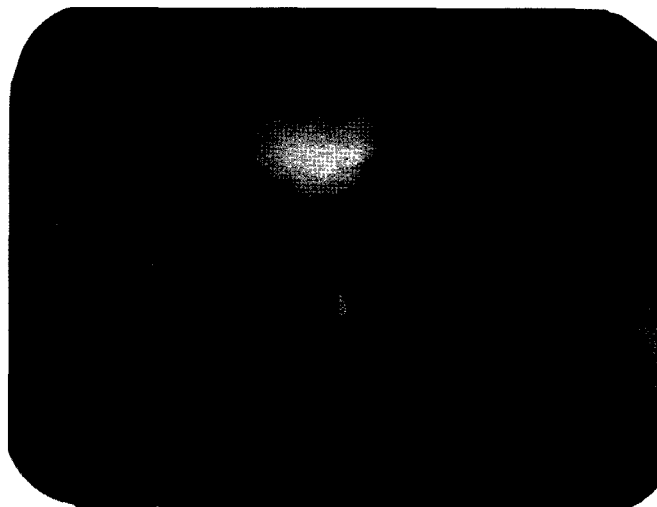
Intraoral periapical radiograph taken after 15 days.
